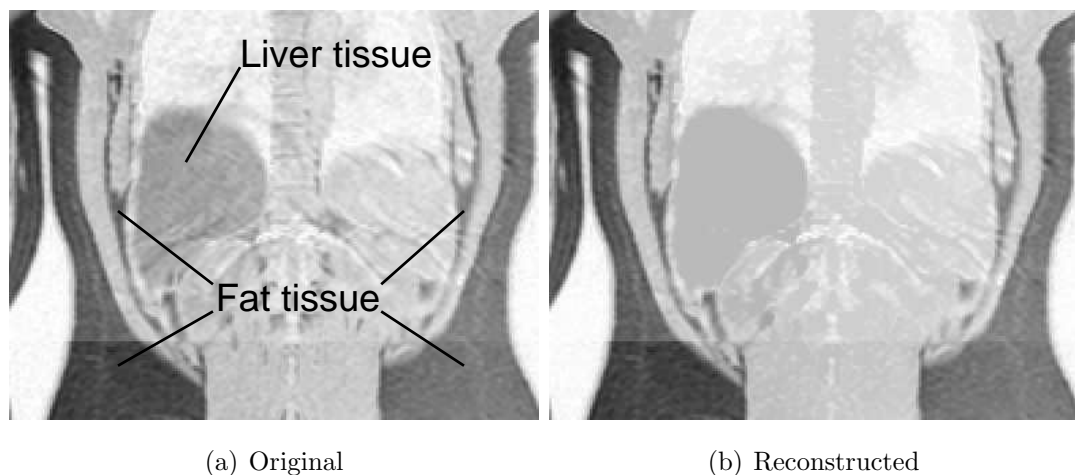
Morphological reconstruction as applied to whole body MRI data so as to suppress signal from the region of the liver while preserving body fat signal. Notice the fat region to the right side of the image, at an intensity level very close to the liver tissue in the original data. After filtering the distinction between the two regions is much clearer.
